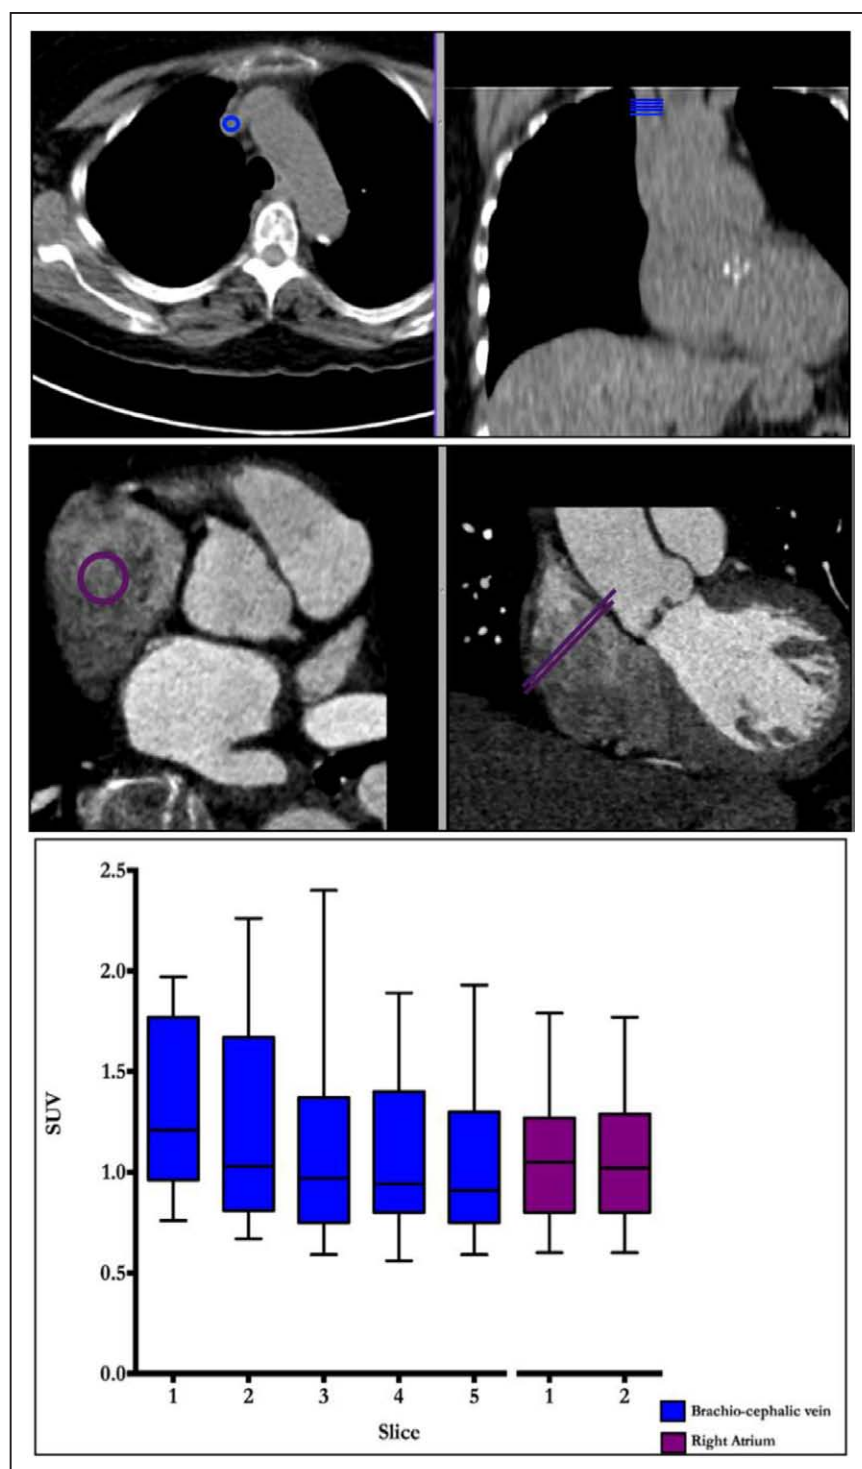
Measuring blood-pool activity in the brachiocephalic vein and the right atrium. Regions of interest for measuring blood-pool activity in the brachiocephalic vein (top) and right atrium (bottom) are shown in the en face of the valve (left) and coronal (right) planes. Note that the right atrium is a much larger structure allowing for larger regions of interest with less potential for partial volume artifact problems related to poor registration. Tukey plot demonstrates mean standard uptake values (SUV) for 5 contiguous slices from brachiocephalic (blue) and 2 from the right atrium (purple). Note the variation in brachiocephalic vein measurements between those taken most caudally vs those taken most cranially.
